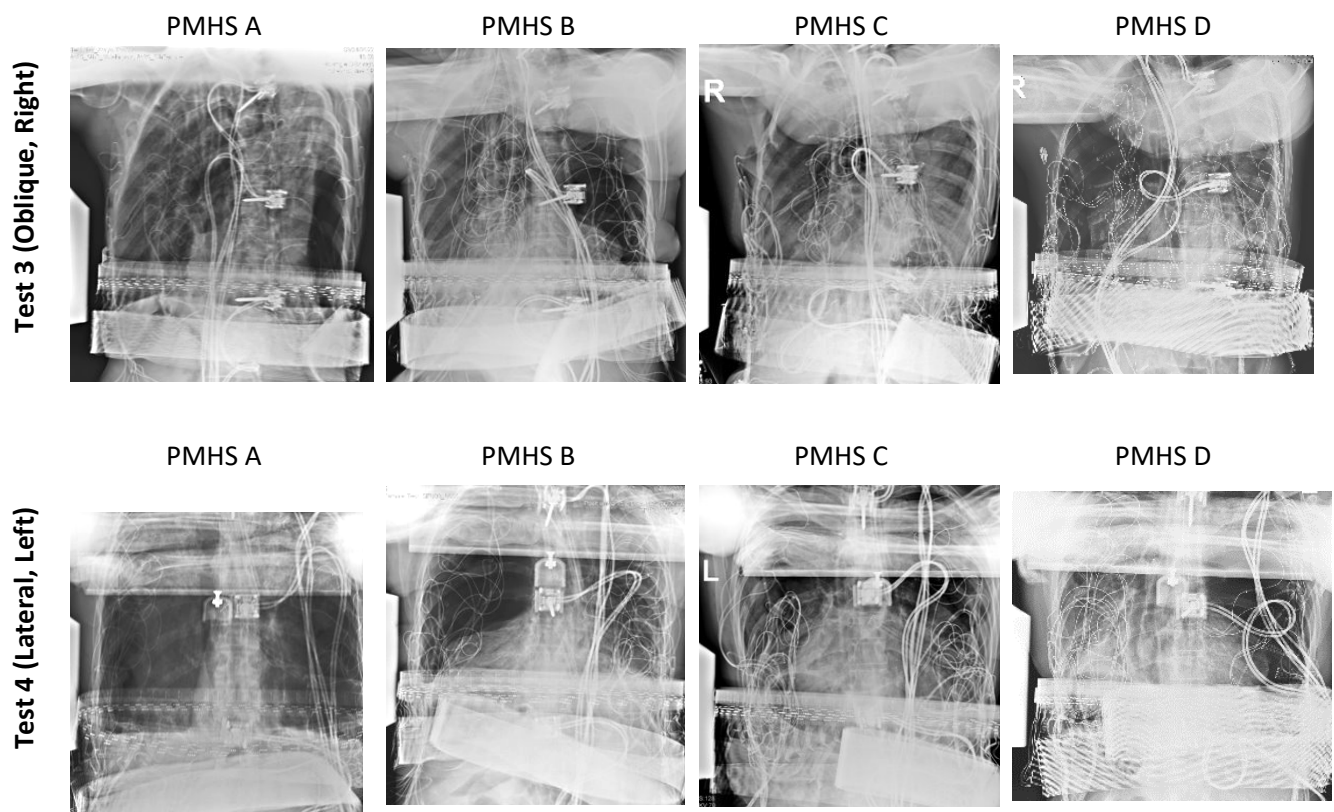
Pre-test, in-position x-rays for Condition II. Test 3 x-rays are shown in the top row and test 4 x-rays are shown in the bottom row. Impactor is shown on the left side of each image.
